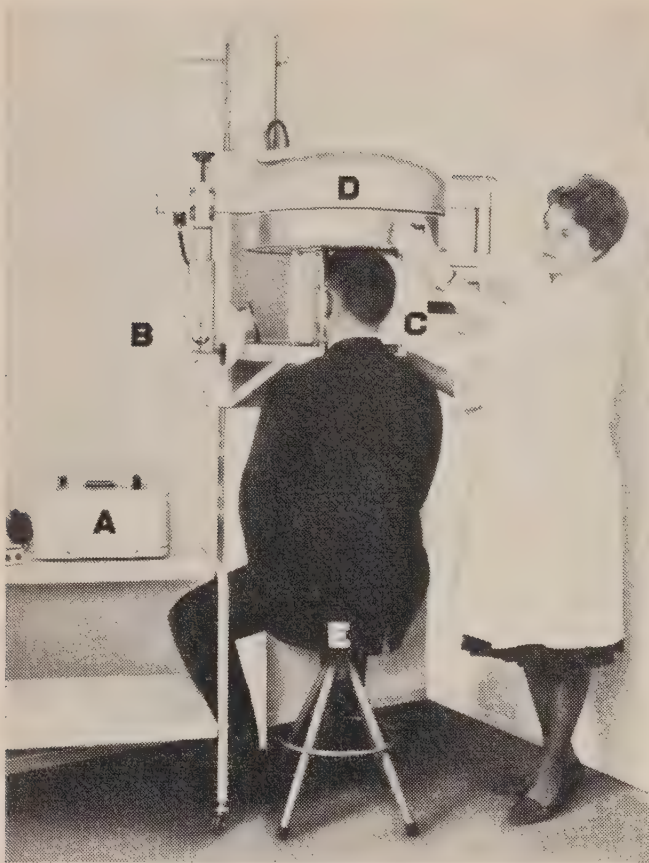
Orthopantomograph using three rotational axes. A, Controls. B, X-ray tube. C, Film cassette holder. D, Motor and cam assembly for rotating x-ray tube and rotating cassette holder around the patient. E, Patient sits on ordinary stool or stands up during exposure. There is no shift at the midline.
